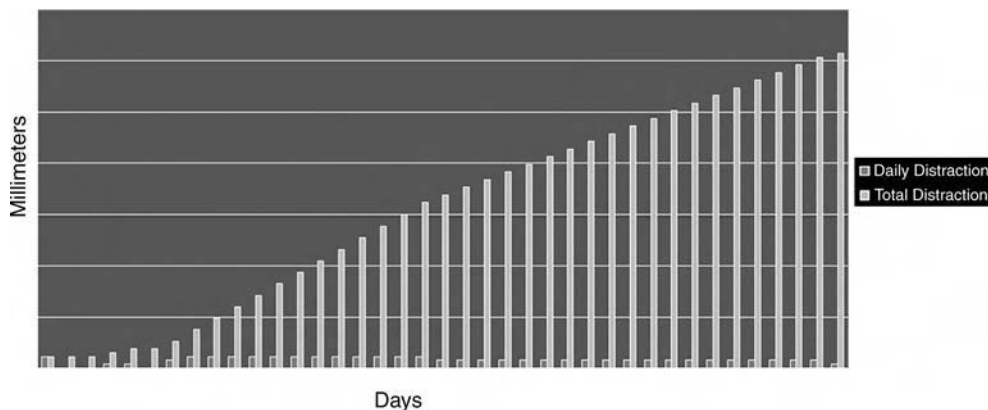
Total Distraction Chart. Five days after surgery: minimal distraction. Initial two weeks of distraction: three pole changes per day. Last phase of distraction: two pole changes. The rate was decreased based on the discrete regeneration noted on the radiographs.
